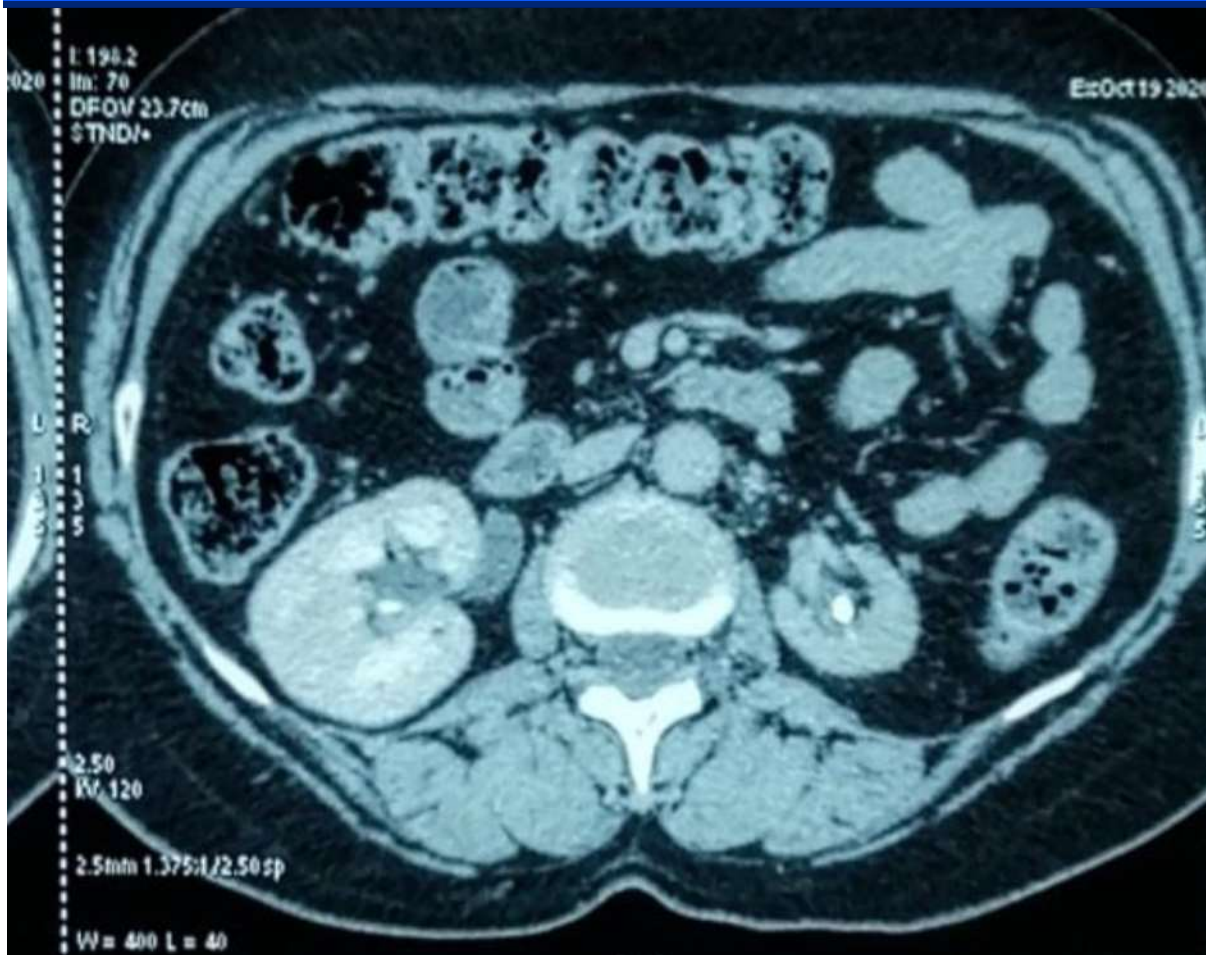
CT shows total regression of RPF with an hypotrophic left kidney .
